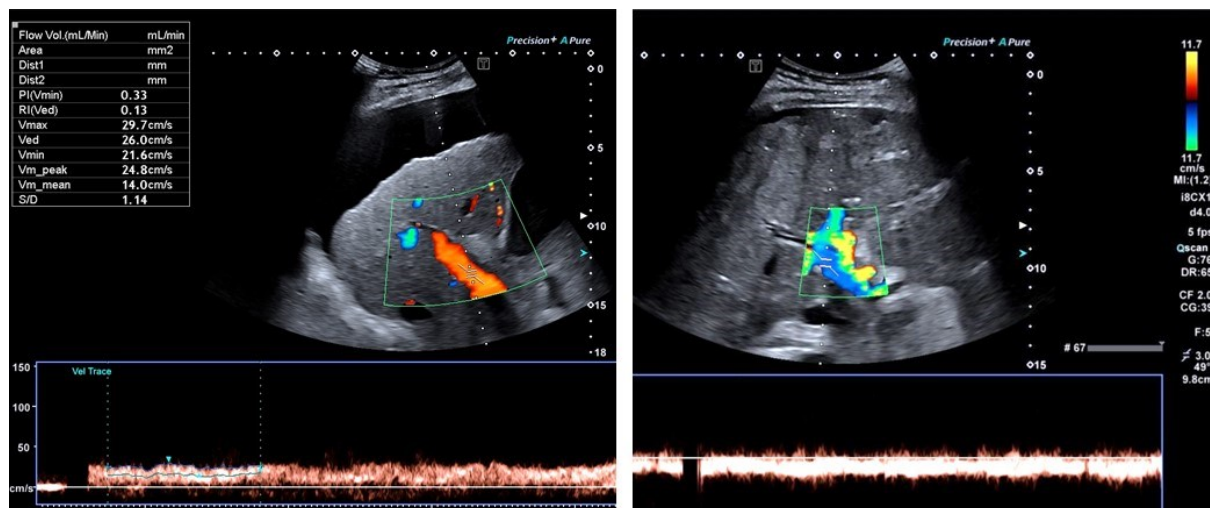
a.4. Spectral Doppler imaging of the portal vein in patients with cirrhosis: hepatopetal flow with diminished velocities (left panel), and hepatofugal flow (coded in blue colour, on the right panel)
